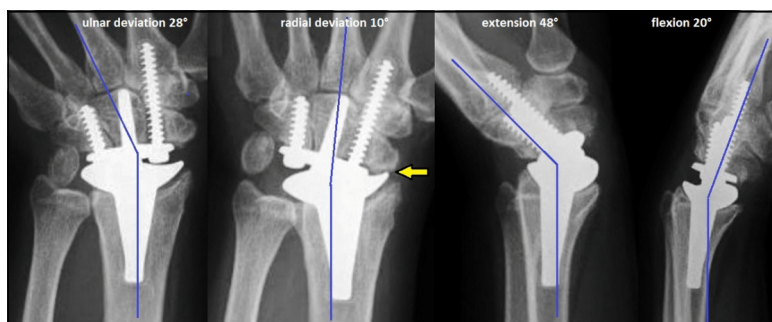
(Example for radial impingement): PA and lateral radiographs with terminal ranges of motion in a 54-year-old female with advanced stage of Kienböck’s disease in her left wrist treated with RE-MOTION™ TWA demonstrating impingement between the radial component and the distal part of scaphoid bone at terminal range of radial deviation with 10° (arrow) at the 3-year follow-up, a diagonal resection at the distal part of scaphoid bone was not done.
